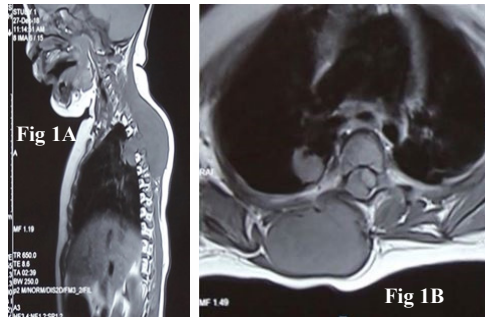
T1 MRI of Dorsal spine (Figure 1 A Sagittal view, Figure 1 B axial view) which shows isointense area at D2-D6 vertebral levels.
